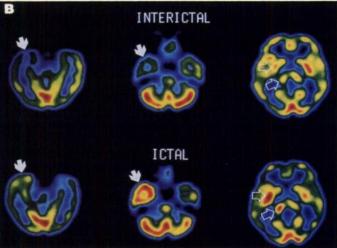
Scans of a 34-yr-old female patient with right temporal lobe epilepsy. (A) Coronal T2-weighted MRI shows increased signal intensity and atrophy of right hippocampus (arrow), suggesting mesial temporal sclerosis. (B) Transaxial reconstructed interictal SPECT images show decreased perfusion of right temporal lobe (closed arrows) and ipsilateral thalamus and basal ganglia (open arrows). On ictal SPECT, right temporal lobe (closed arrows) and right thalamus and basal ganglia (open arrows) show increased perfusion when compared with the left side.
